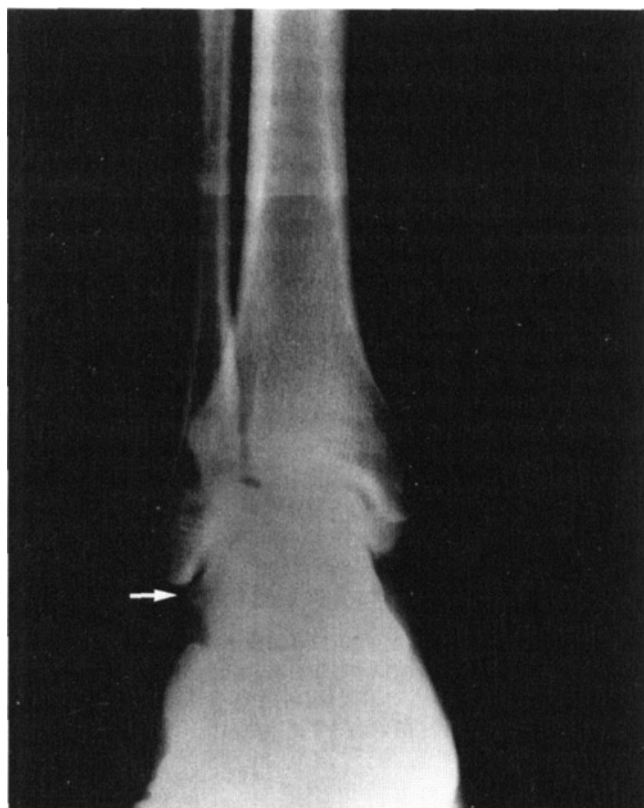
Plain radiograph of the ankle revealing a subtle bony prominence of the lateral talus.
